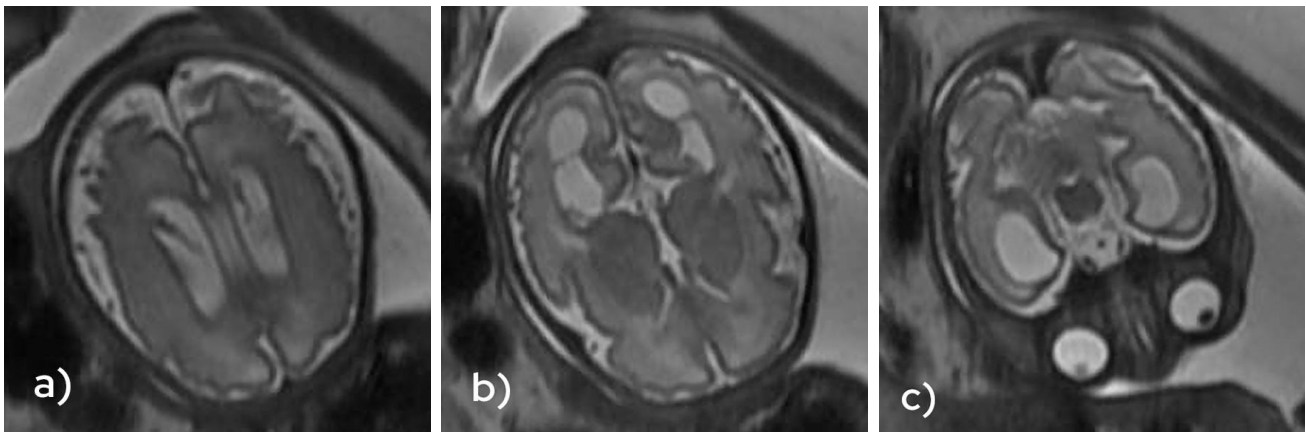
MRI of fetal brain: a) simplified gyral pattern with mild ventriculomegaly, b) dilated occipital horns of lateral ventricles with intraventricular septations, c) dilated temporal horns of lateral ventricles with white matter rarefaction
